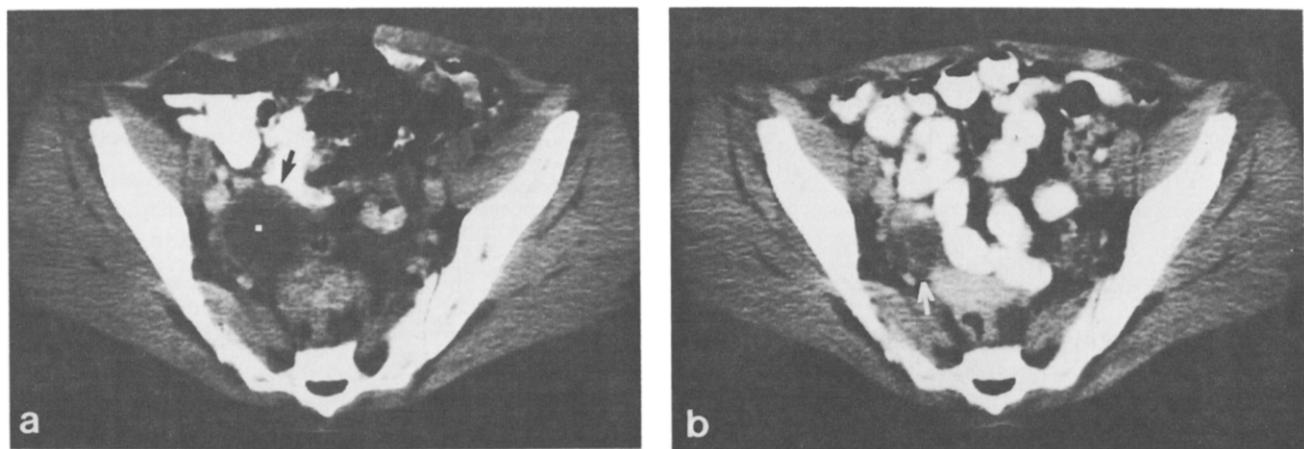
Computed tomography scan of patient no. 7 shows a melanoma metastasis of the right ovary: (a) before MAb R-24 treatment; (b) after MAb R-24 treatment; arrows point to sites of disease.
